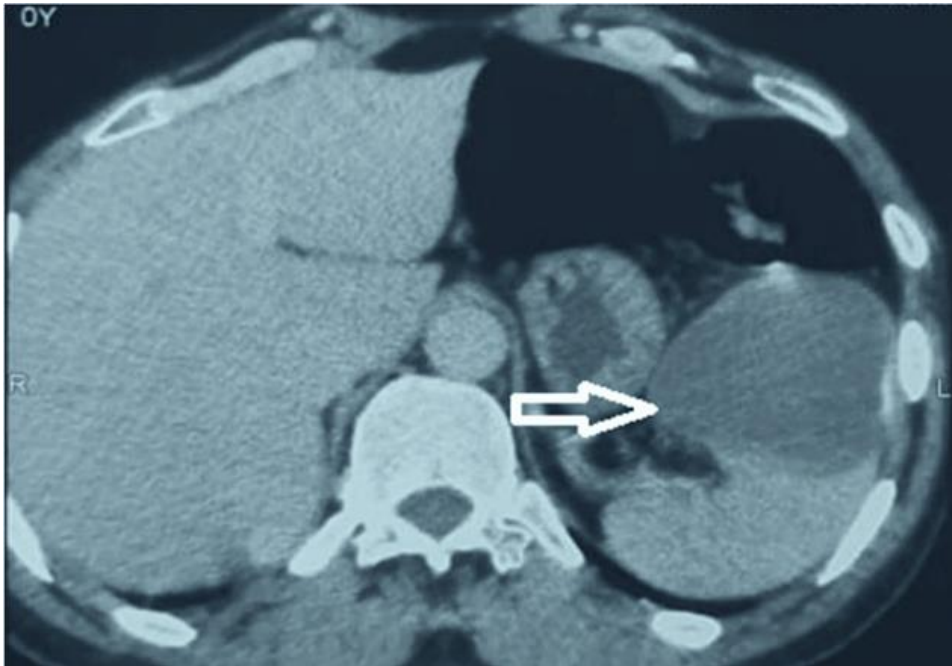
axial abdominal computed tomography (CT) scan showing an uninoculated and well-defined cystic mass in the upper polar of the spleen measuring 115 x 75 mm (white arrow)
